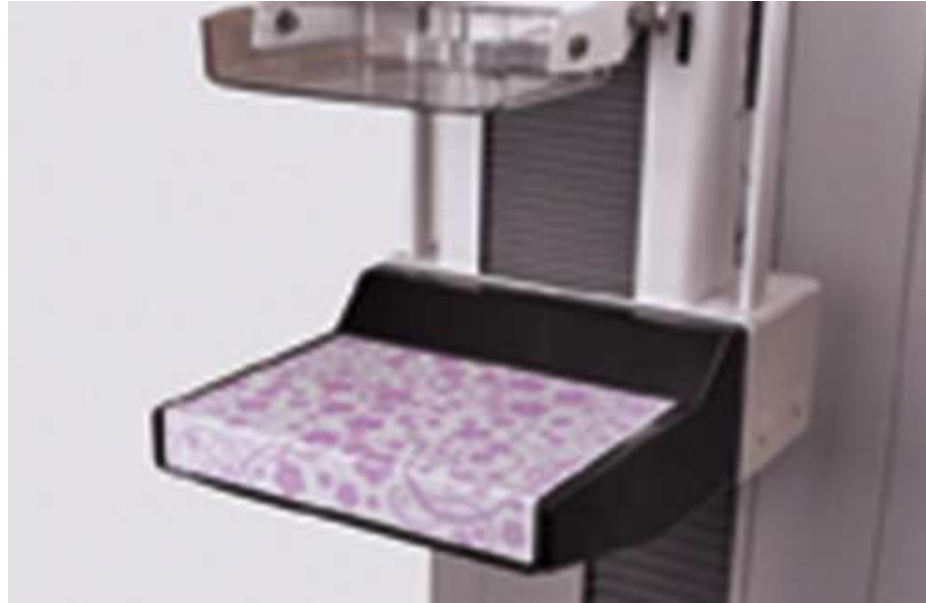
Breast cushions are sometimes used to provide a more comfortable environment and examination for the patient. Courtesy Beekley Corp., Bristol, CT.
